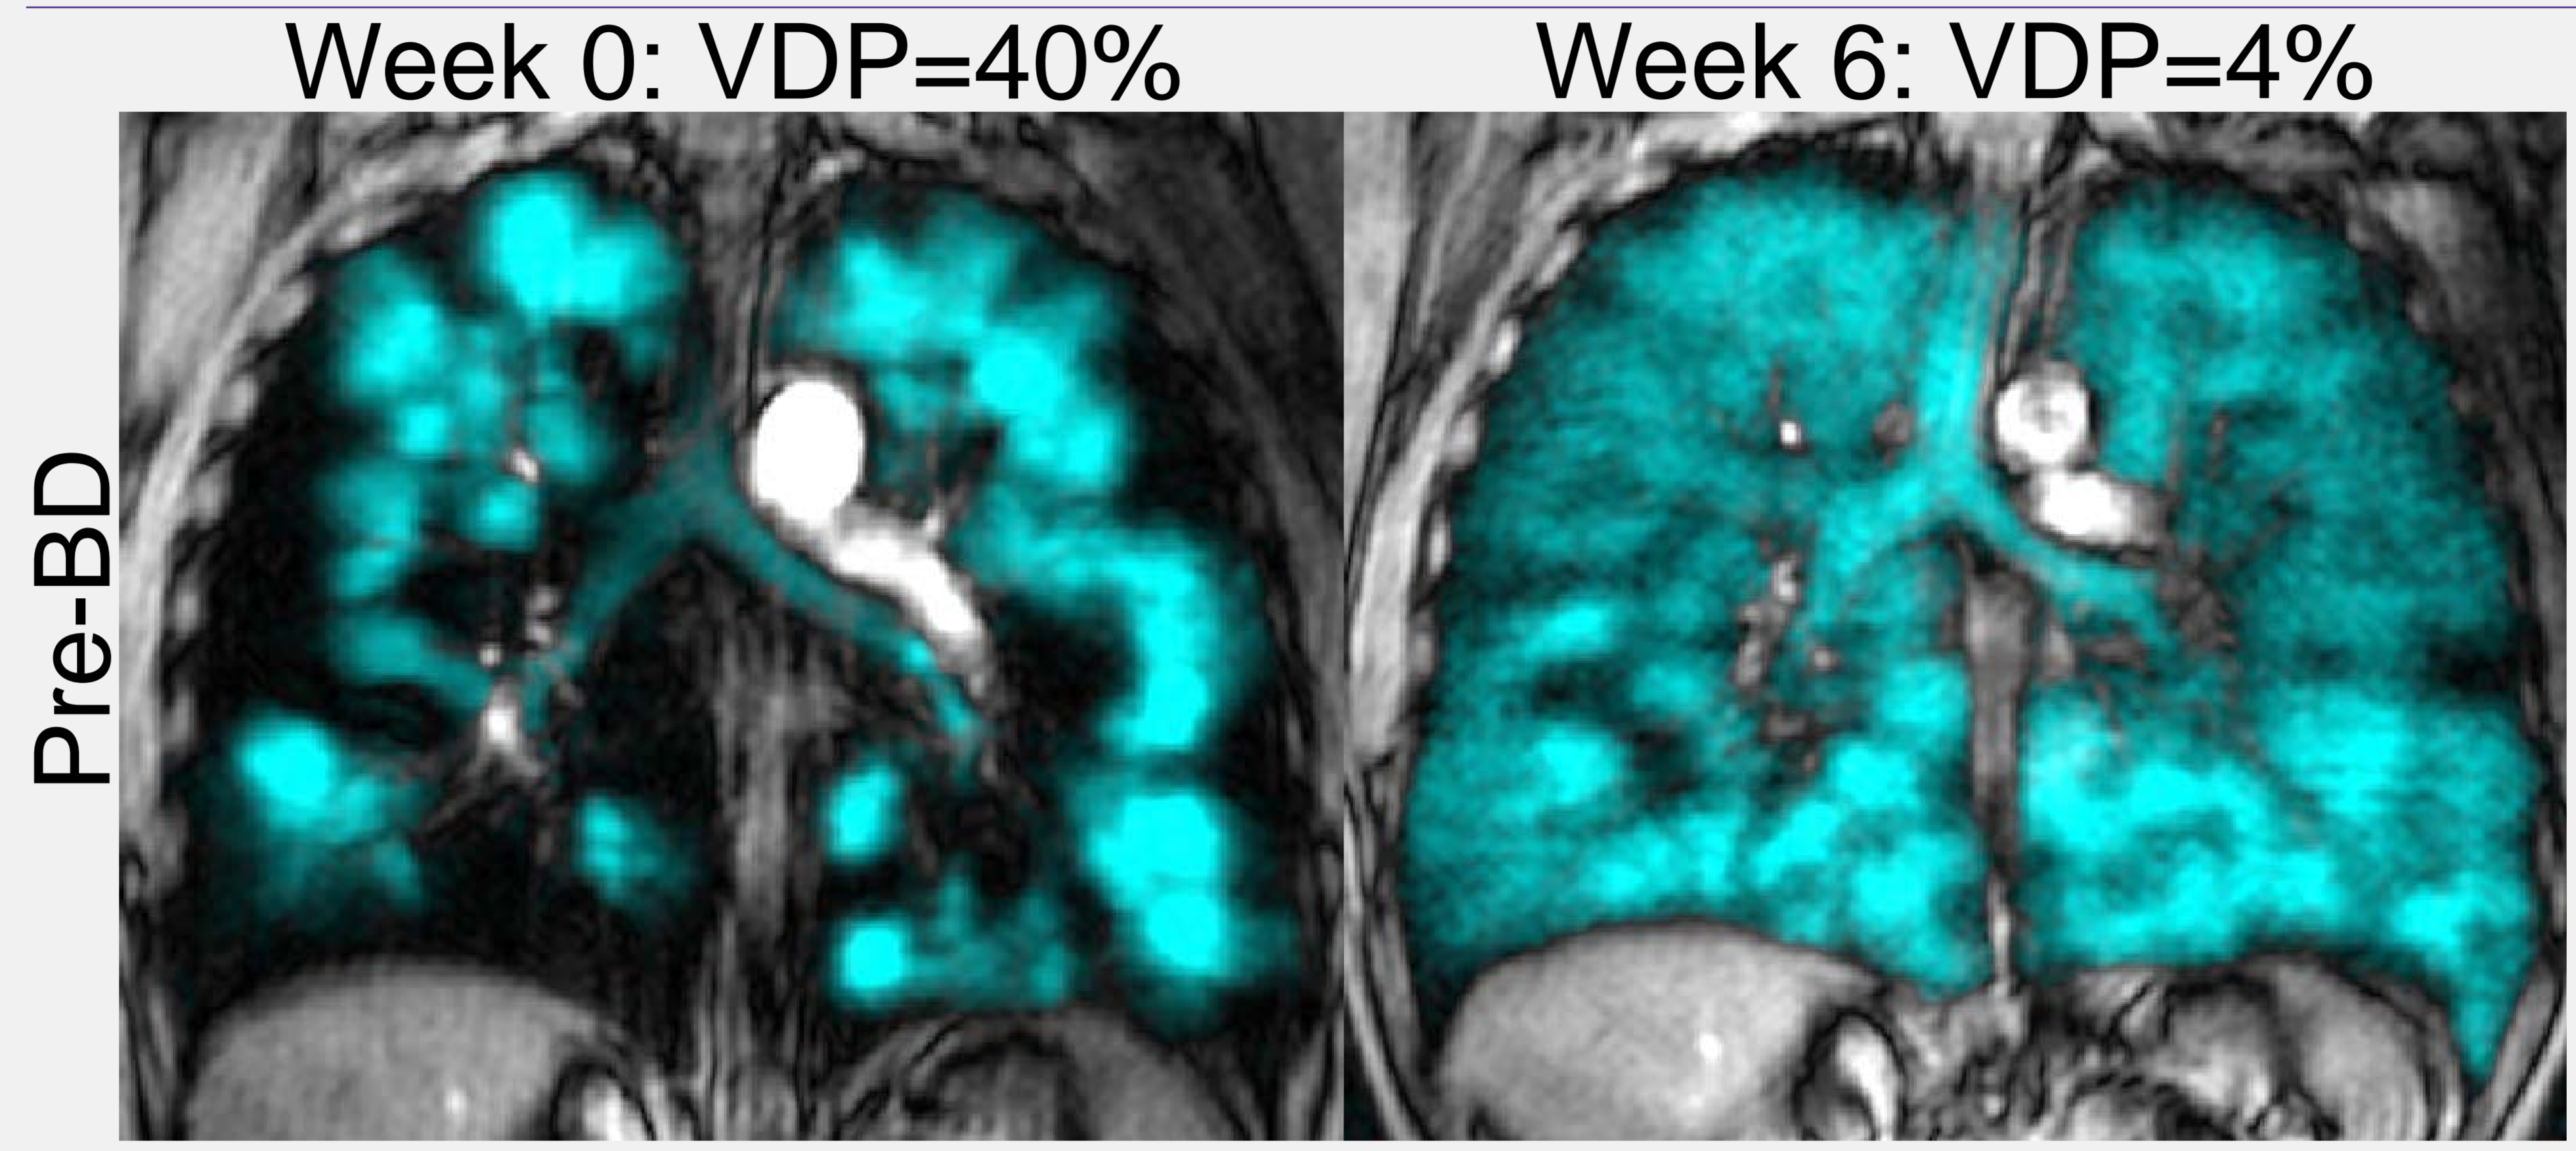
Pre-BD MRI VDP at 0-week and 6-week follow-up. V1 pre-BD FEV₁ %_{pred}=39%; ACQ-6=1.8; AQLQ=4.9; pre-BD VDP=40%; mucus-score=10. V2 pre-BD FEV₁ %_{pred}=68%; ACQ-6=0.0; AQLQ=6.6; pre-BD VDP=4%.
